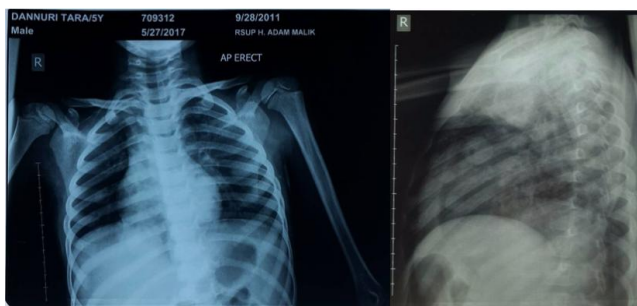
Chest X-Ray Pre
